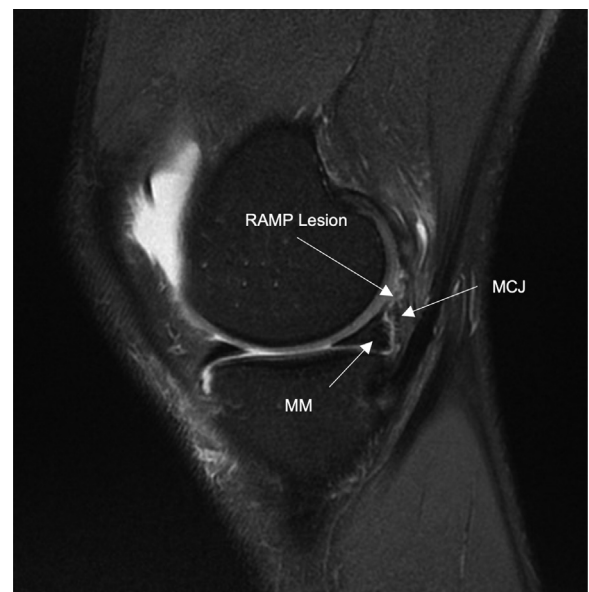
Typical MRI sign of a ramp lesion in an ACL-deficient knee. In this sagittal slice MRI of the right knee, a hyper T2-weighted signal can be observed at the meniscocapsular junction of the posterior part of the medial meniscus posterior horn. Abbreviations: ACL, anterior cruciate ligament; MCJ, meniscocapsular junction; MM, medial meniscus; MRI, magnetic resonance imaging.
